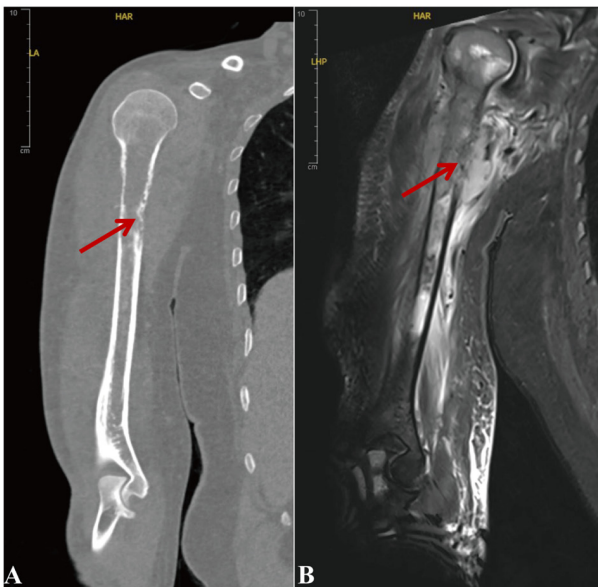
Imaging findings of the right humerus. (A) Computed tomography showing bone destruction in the upper to mid humerus and localized lytic lesions in the scapula. (B) Magnetic resonance imaging revealing cortical disruption, heterogeneous signal intensities and surrounding soft-tissue masses with mixed high and low fat-suppressed T2-weighted imaging signals, consistent with malignancy. The arrows indicate the lytic bone lesion
